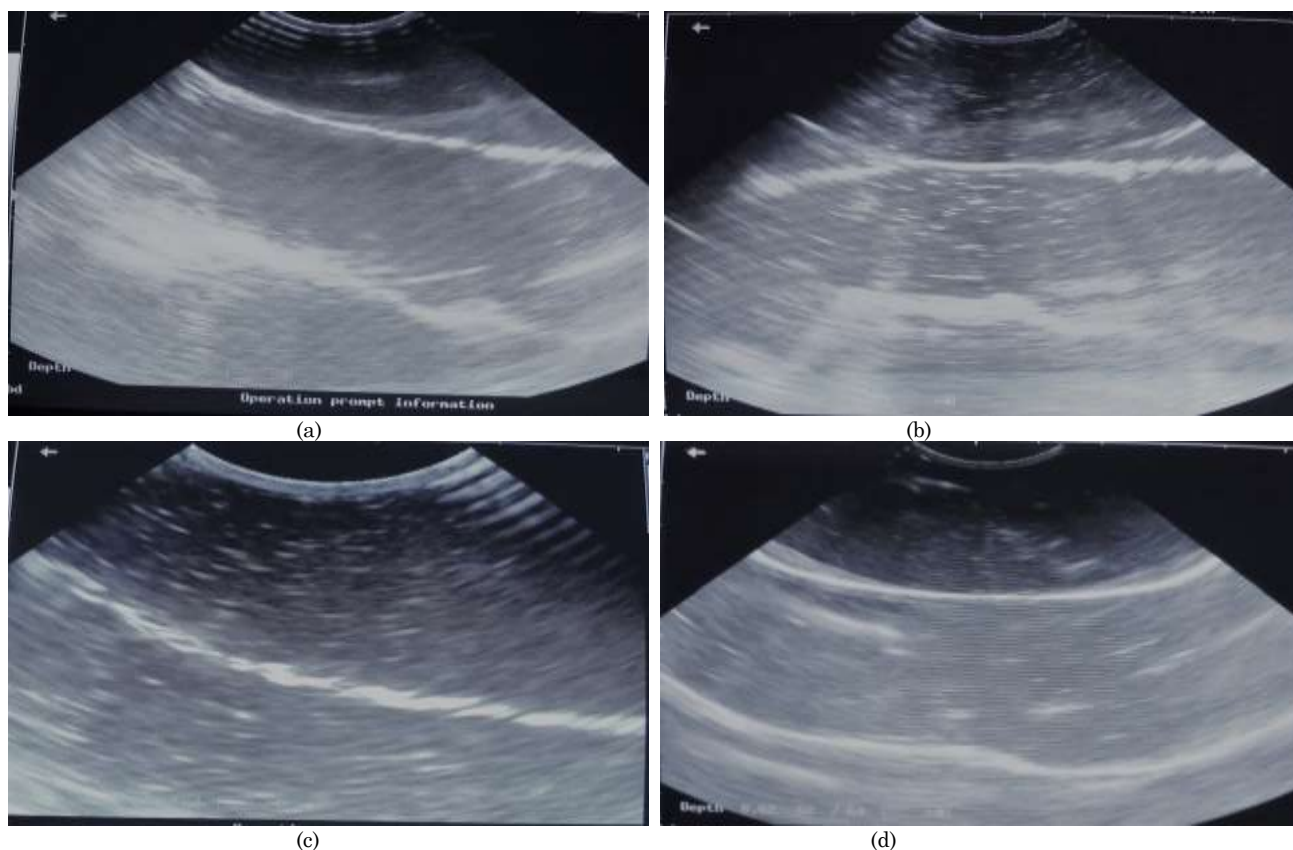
Ultrasonography of sorafenib loaded NBs. (A) PBS, (B and C) sorafenib loaded nanobubbles into same PBS, and (D) Representative images taken after ultrasound application (5 MHz) for 15 min
